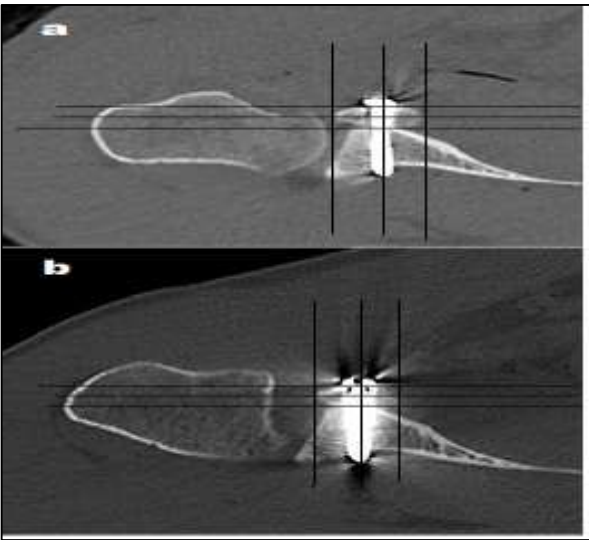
CT scan showing the coracoid bone graft around the proximal screw:
